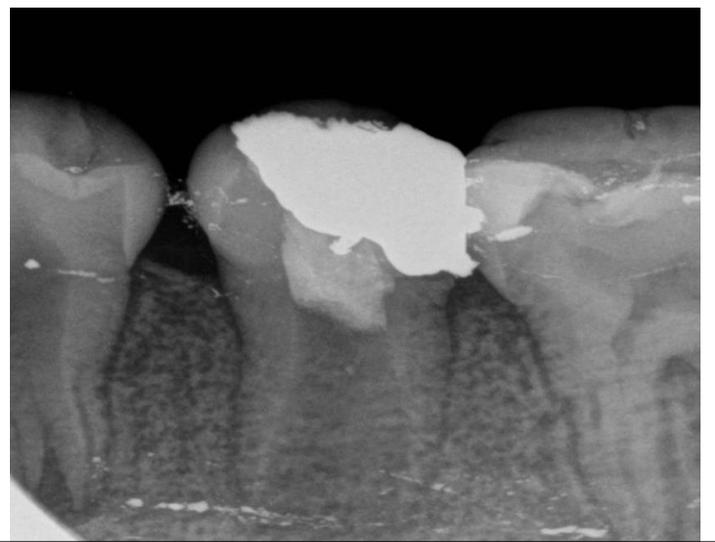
Immediate Post Op x-ray
